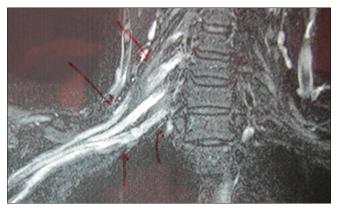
Magnetic resonance imaging brachial plexus showing hypertrophy of the right plexus with contrast enhancement
